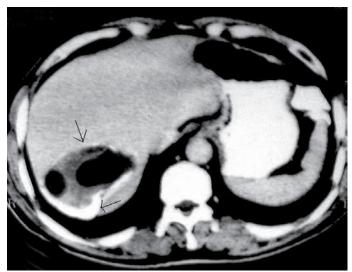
Computed tomography scan revealed a lobulated, heterogeneous, cystic mass, with partially calcified wall and measuring 4x5 cm in the posterior aspect of the right hepatic lobe (segment VII) in 1999. The arrows show the hydatid cyst and its calcified wall
